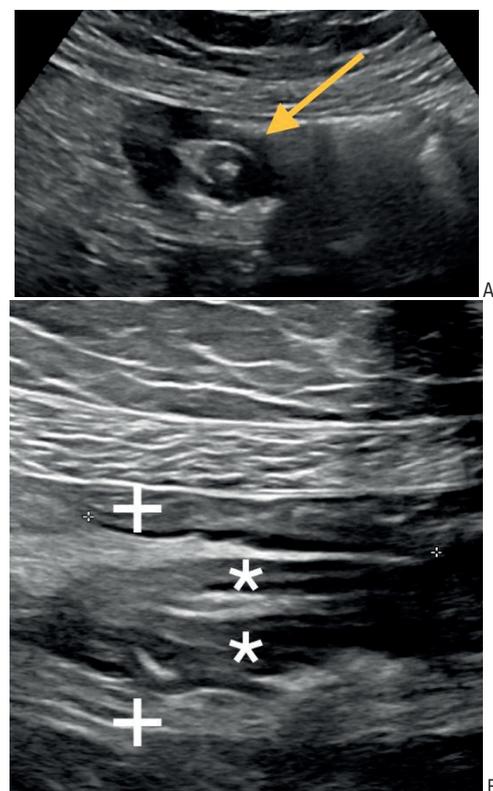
Ultrasound image showing: (A) “target sign”; (B) “sandwich sign” (the proximal, intussuscepted part of the small bowel is marked with the symbol “+”, and the distal part with “*”).
